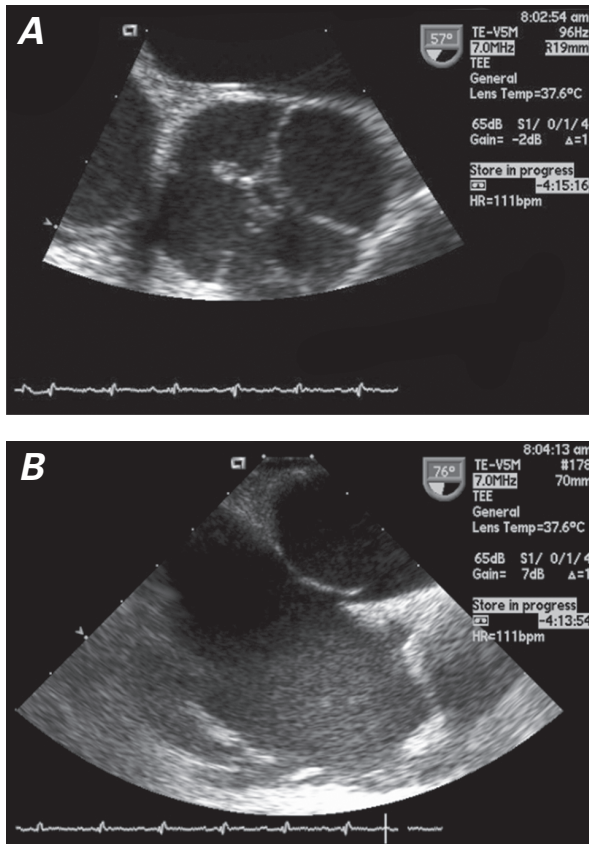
Transesophageal echocardiography shows A) a quadricuspid aortic valve and B) a patent foramen ovale.
